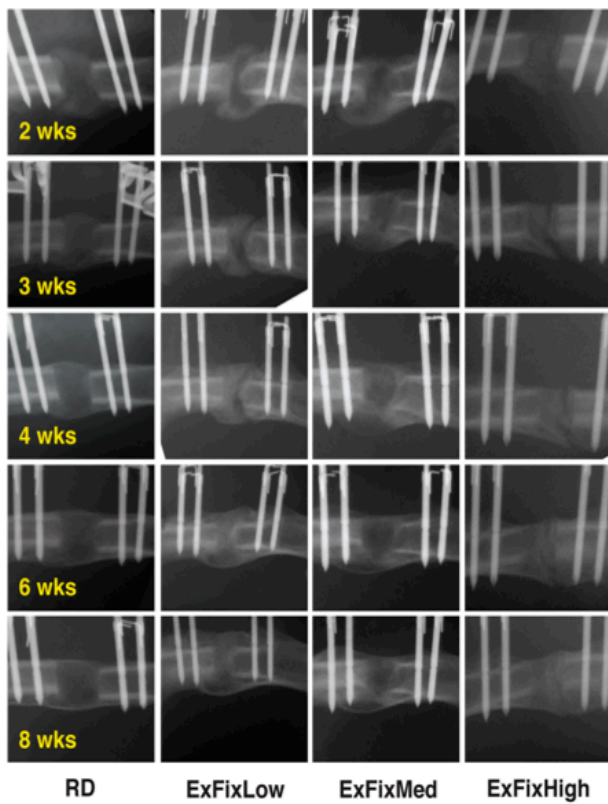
Serial radiographs of defects stabilized with low (ExFixLow), medium (ExFixMed) and high (ExFixHigh) stiffness fixators and subjected to reverse dynamization (RD)
